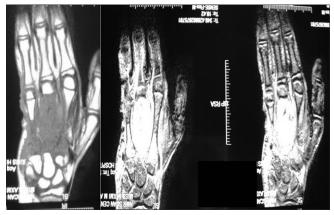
Magnetic resonance imaging revealing marrow signal changes involving the second, third and fourth metacarpals with cortical breakdown of third metacarpal in T1 and T2 sequences
